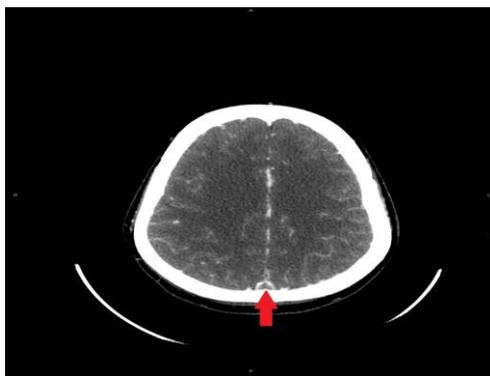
CT Brain with IV Contrast: Empty Delta Sign
